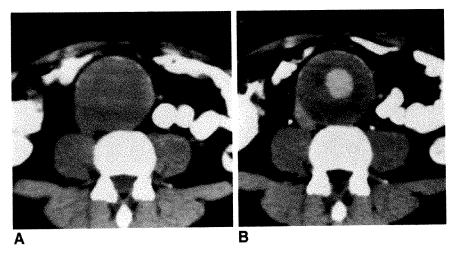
A and B, Preinfusion (A) and postinfusion (B) CT scans show importance of IV contrast material to differentiate lumen from thromhus.
